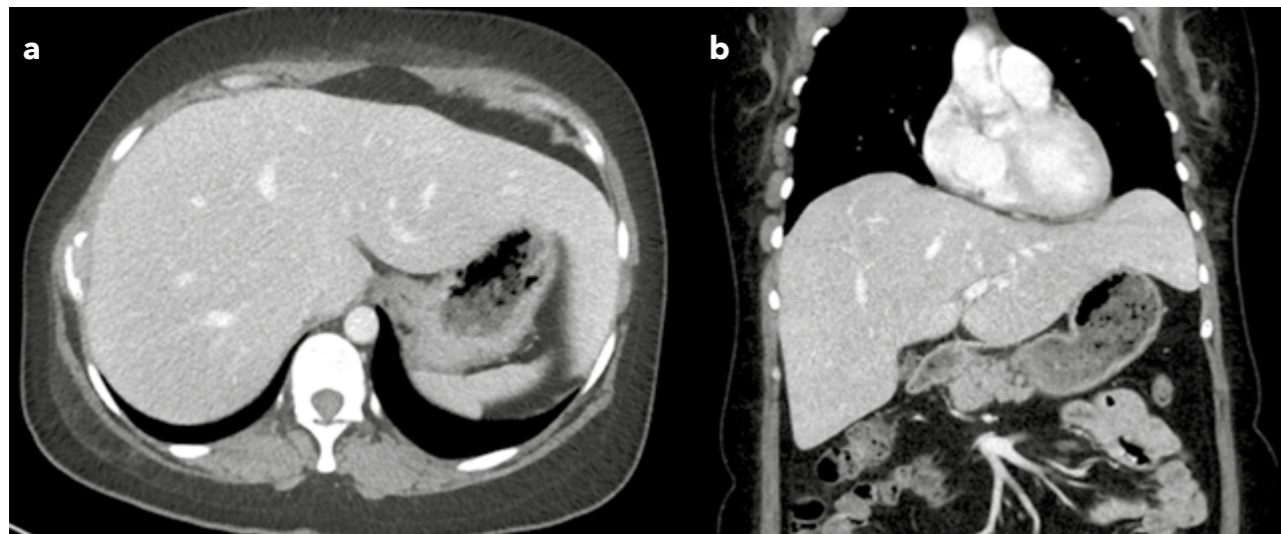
Contrast-enhanced CT abdomen (a) Axial and (b) Coronal.
